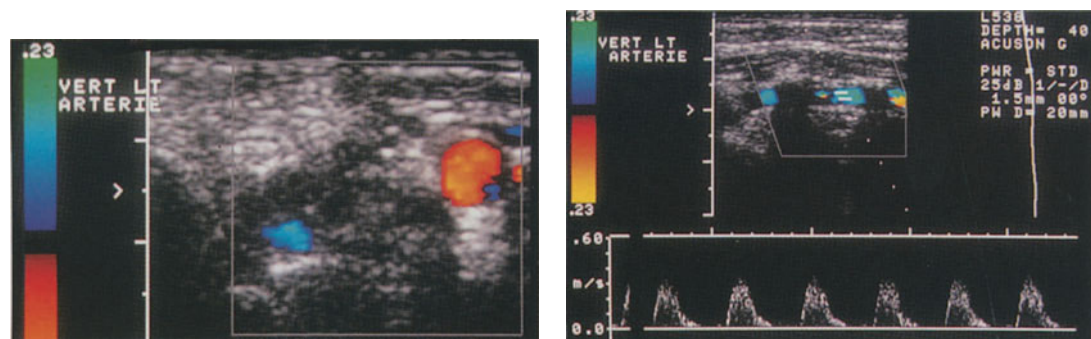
(left) Transverse color-coded Doppler sonogram also shows reversed flow (blue) in VA compared to CCA (red)
